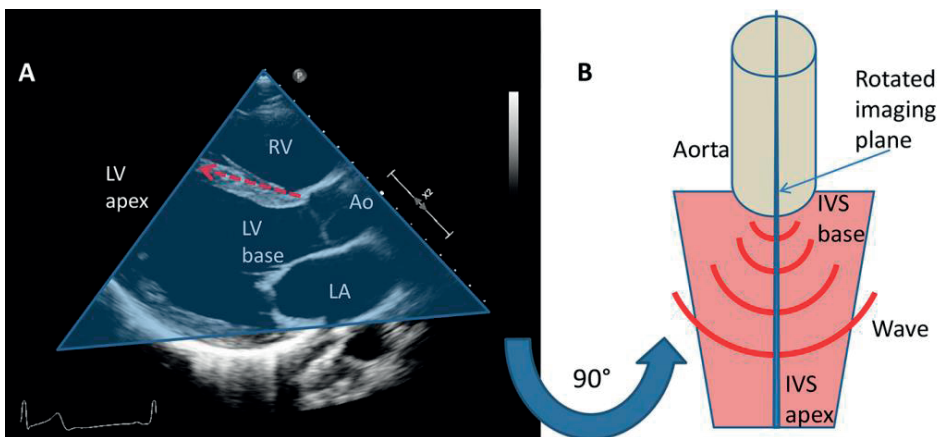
Relation between the shear wave propagation and the imaging plane in the parasternal long axis view (Source: personal collection). A: actual echocardiographic image. The shear waves appear at the valvular annulus and course along the interventricular septum (IVS) to the apex (arrow). B: the imaging plane represented by the transparent triangle in panel A is rotated 90° counterclockwise, with the LV apex towards the viewer. Shear waves generated at the atrioventricular or aortic annulus are perpendicular to the imaging plane (represented by the central blue line).
